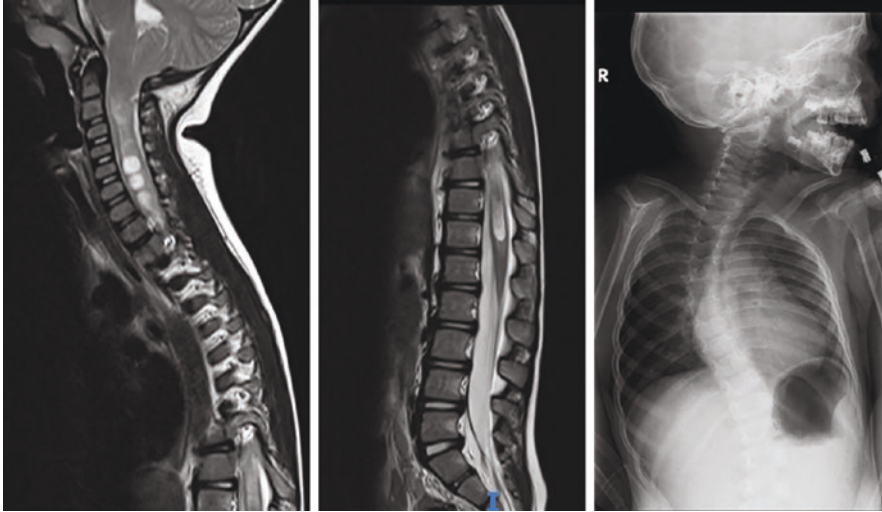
T2-weighted sagittal cervico-thoracic (left image) and lumbar (middle image) MRI presenting a Chiari type I malformation with associated SM. In the anteroposterior X-ray, an associated scoliosis is clearly seen (right image)
